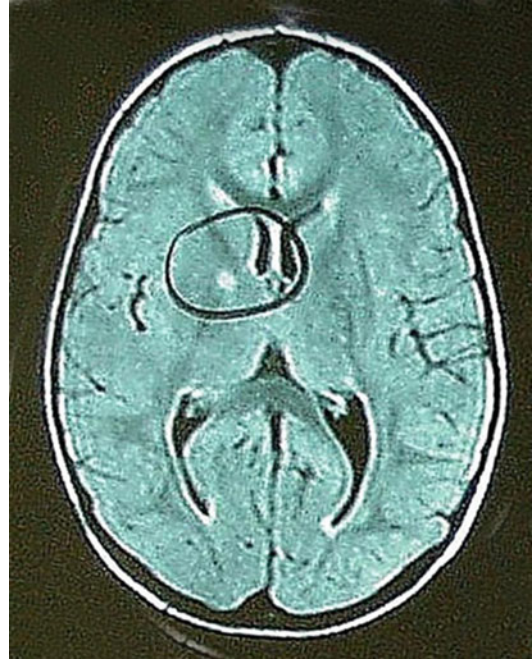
MRI of the brain showing a hamartomatous lesion of the right globus pallidus. This patient has numerous cutaneous café-au-lait spots of varying size and typical axillary freckles. He was shown to have a truncating mutation in the segment 3 of the neurofibromin (*NF1*) gene
